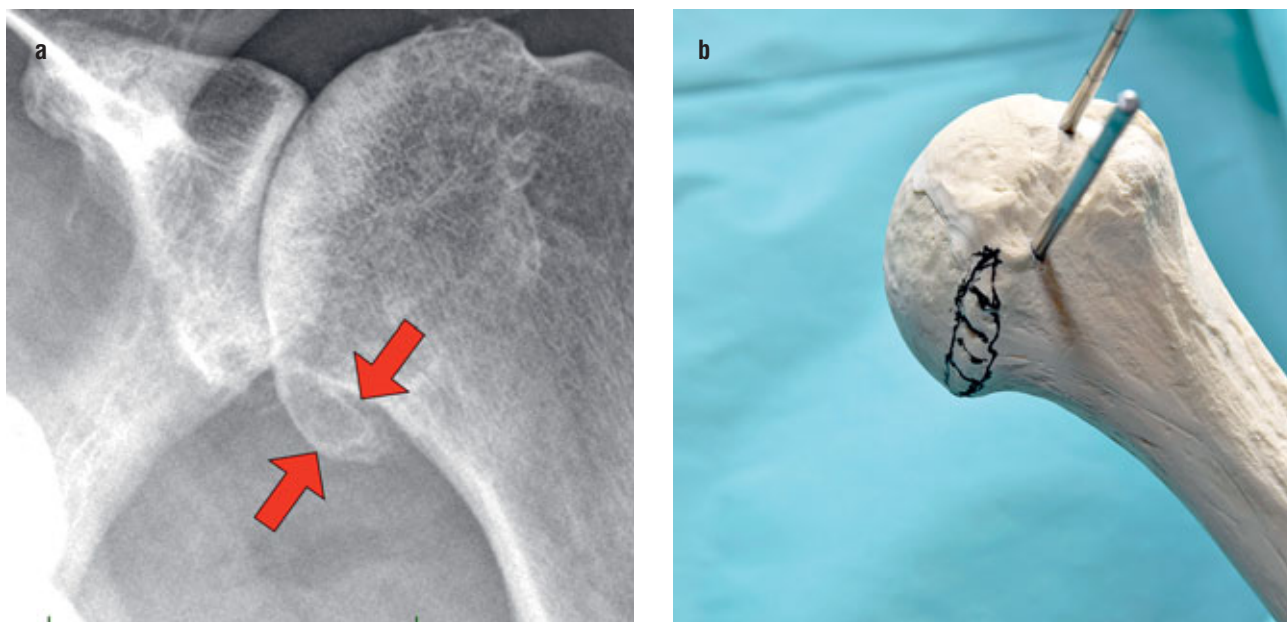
a, b. Typical caudal osteophyte. Radiograph on the left, visualisation on a model (black marked out area) on the right.
